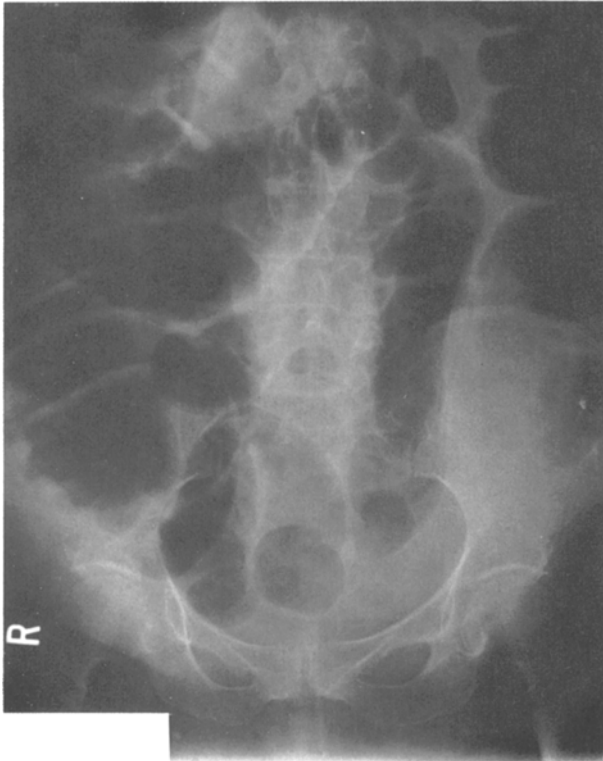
Admission abdominal radiograph demonstrates large bowel obstruction extending to sigmoid colon.
